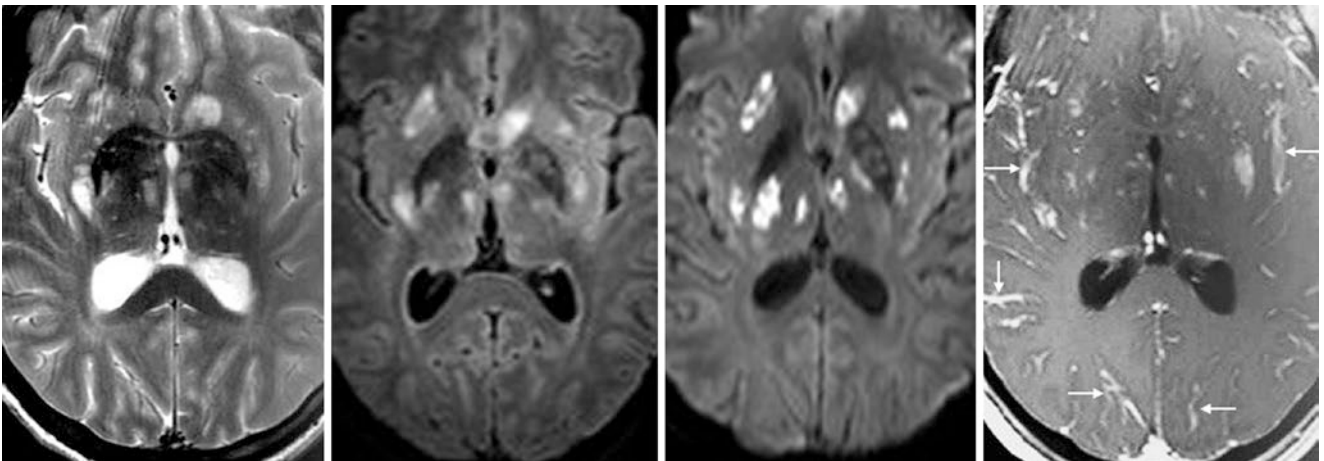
Comparison case of cryptococcal meningitis. On a 3T MRI, an HIV+ 33 year old had numerous bright basal ganglia lesions on T2WI (*left*), which were also bright on FLAIR (*left middle*) and DWI
